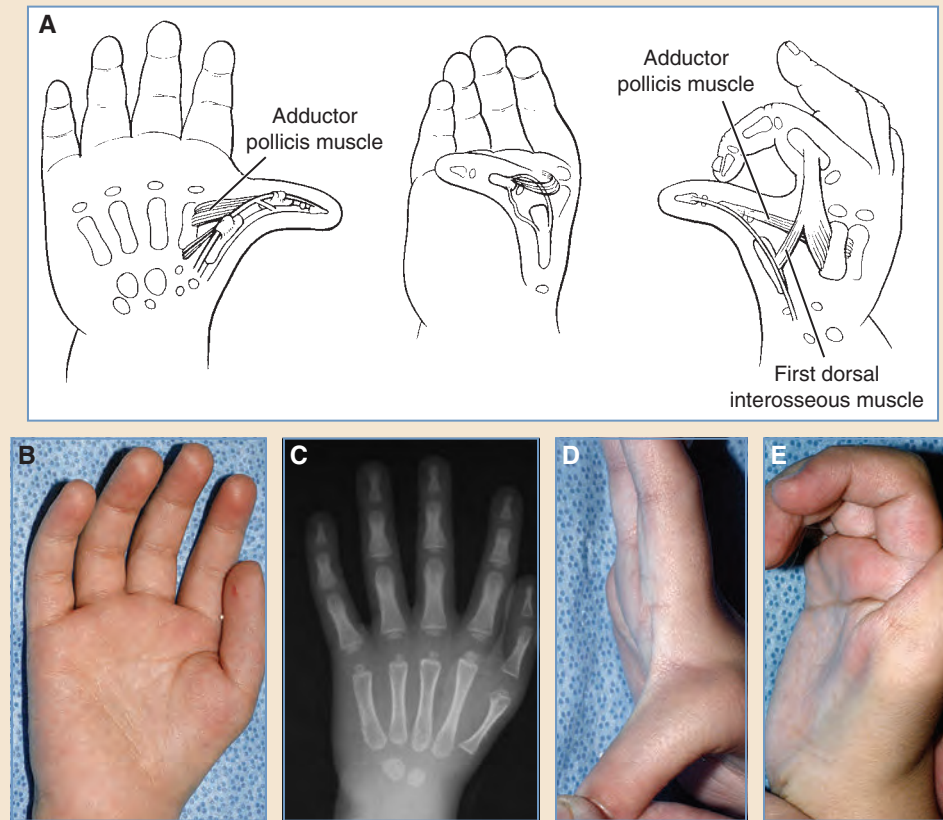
Type IIIA thumb hypoplasia—severe. A, These thumbs exhibit more severe skeletal hypoplasia, including the carpal bones. Median nerve-innervated thumb intrinsic muscles are severely hypoplastic or absent, and the ulnar-innervated muscles are present but weak. Extrinsic tendons are abnormal, the “pollex abductus” deformity is frequent, the first web space is small, and the MP joint is unstable (more on the ulnar than the radial sides). The CMC joint and thumb metacarpal are intact in IIIA thumbs. B-E, Clinical photographs and a radiograph showing a short, slender metacarpal, an intact CMC joint, severe hypoplasia of the thenar eminence, and a lax MP joint. The absent IP flexion crease is indicative of a deficient or absent FPL.
